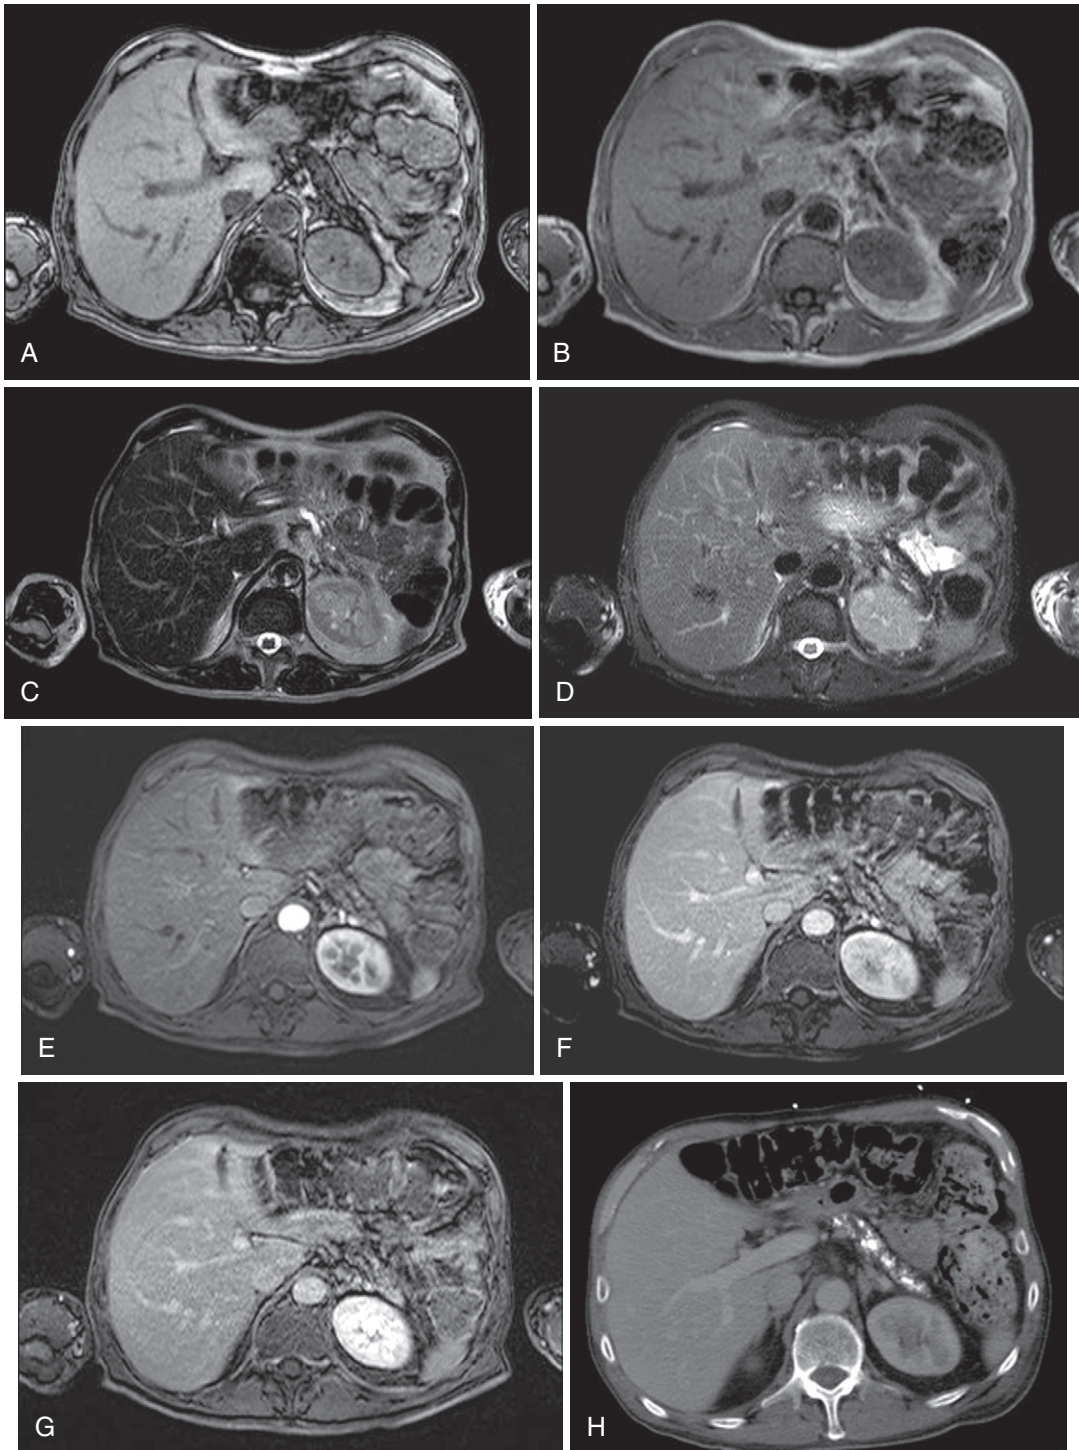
Chronic calcific pancreatitis. Out-of-phase (A) and in-phase (B) T1-weighted gradient recalled-echo images demonstrate atrophy of the glandular pancreatic parenchyma with blooming on the in-phase (B) image related to pancreatic calcifications. T2-weighted (C) and fat-suppressed T2-weighted (D) images of the pancreas reveal multiple areas of pancreatic duct stricturing and dilatation. Pre-contrast (E), arterial (F), and delayed (G) fat-suppressed T1-weighted gradient recalled-echo images depict the decreased T1-weighted pancreatic signal intensity with mottled early enhancement and homogeneous delayed enhancement. Enhanced computed tomography (CT; H) image better depicts the extent of pancreatic parenchymal calcification.
